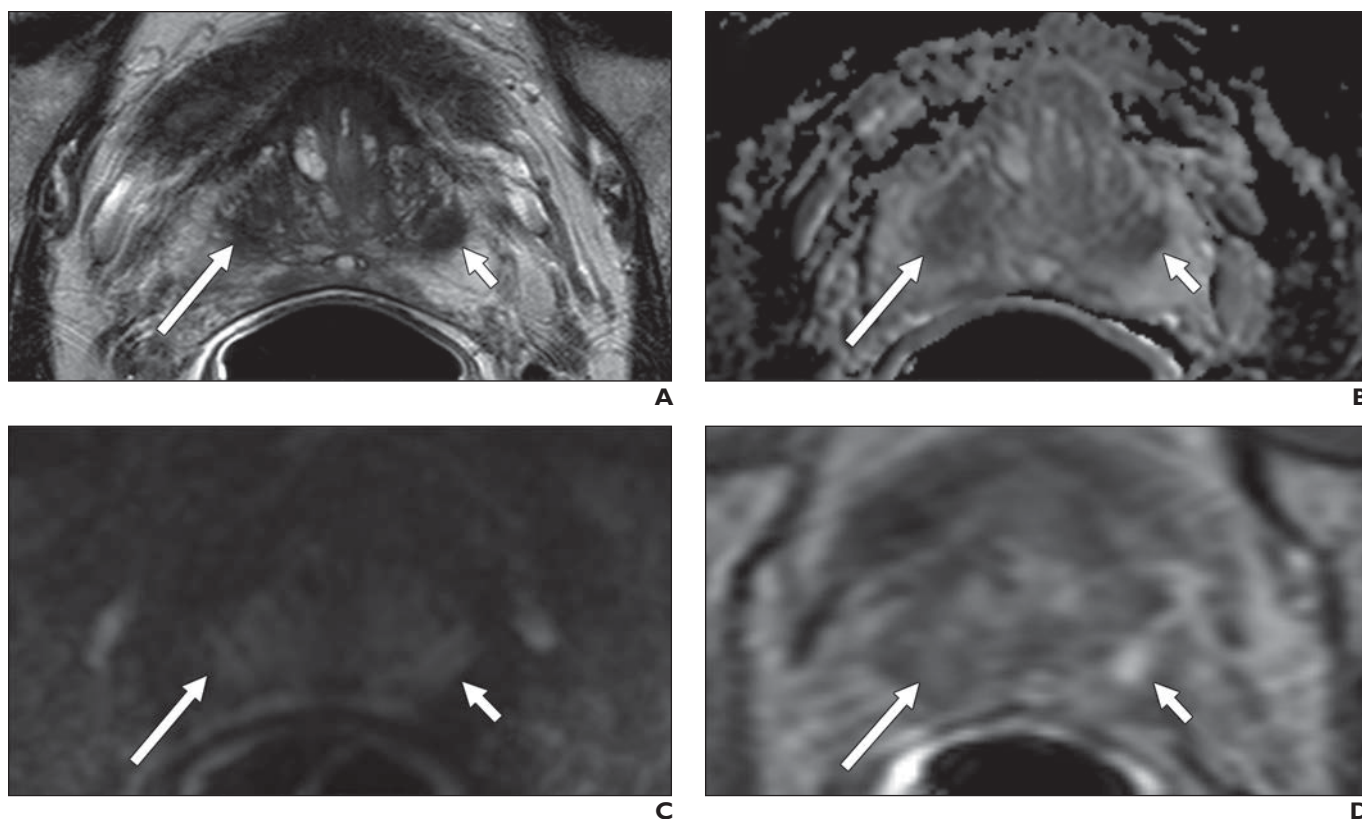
62-year-old man with serum prostate-specific antigen value of 6.4 ng/mL who was referred for multiparametric MRI (mpMRI).
